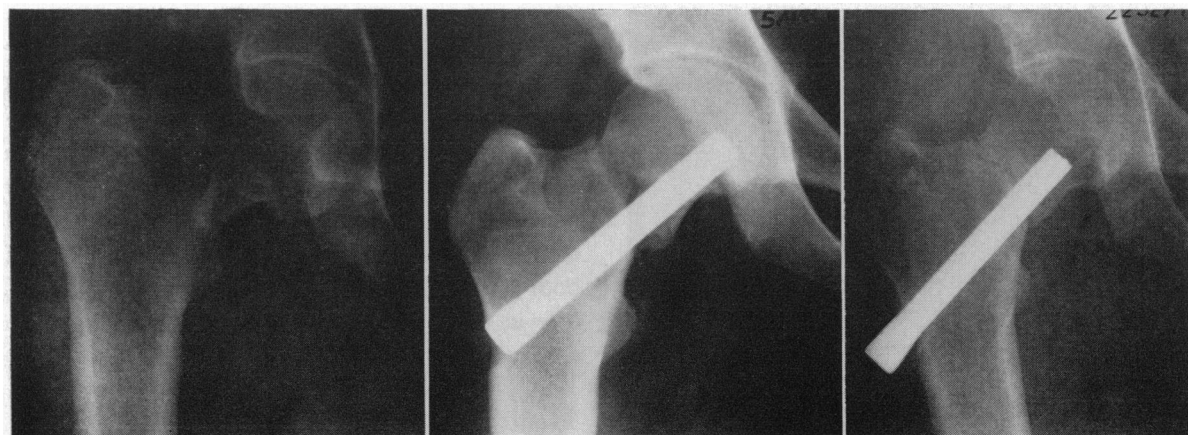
Right hip of a 24-year-old recruit who had had pain in the groin and thigh for two weeks. During marching, the right leg suddenly gave way. At left is initial x-ray film, anteroposterior view. Center panel, five days later, after Smith-Petersen nailing. Despite poor reduction, the fracture eventually healed. Film at right was taken six months after nailing. The nail was removed one year after insertion.
